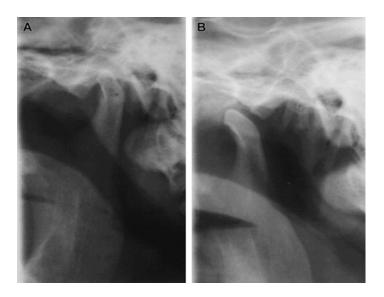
Radiographic picture of unilateral luxation, A: Closed mouth, B: Mandibular condyle luxates into an anterior position of the eminence.
